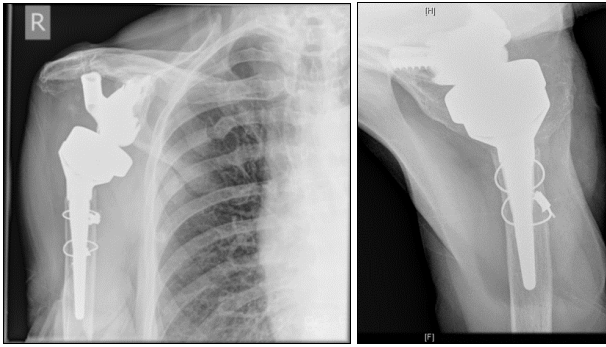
Radiographs at 30 months follow up.
